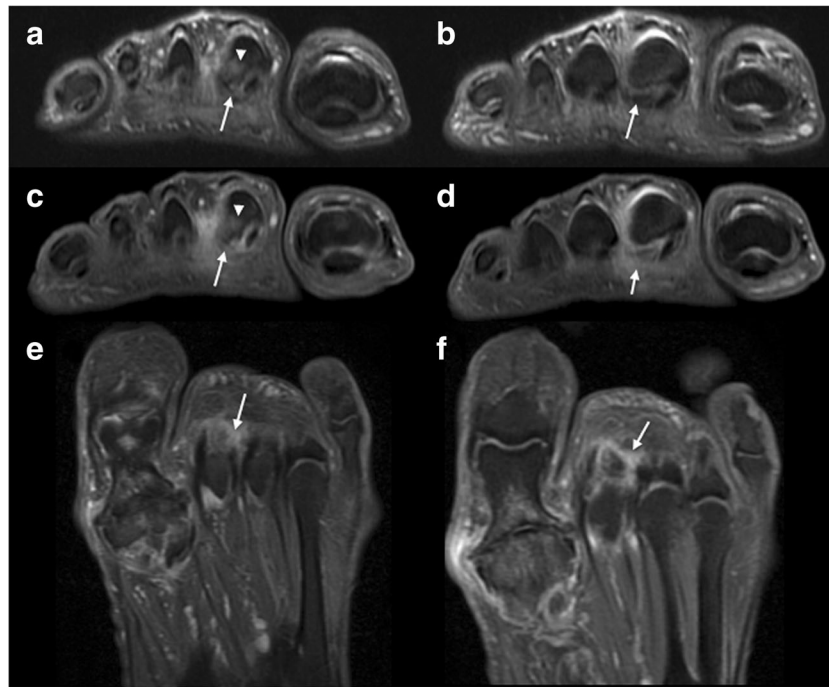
Coronal (a–d) and axial (e–f) axis of a 73-year-old woman with left forefoot pain and hallux arthrosis. Images a and b are fat-suppressed PD images, and c–f are contrast-enhanced fat-suppressed T1-weighted images. Images (a, c, e and f) show discontinuity of the PCL with the most lateral insertion of the PP into the base of the proximal phalanx, in association with hyper-vascularized/fibrous tissue, and a lesion on an
